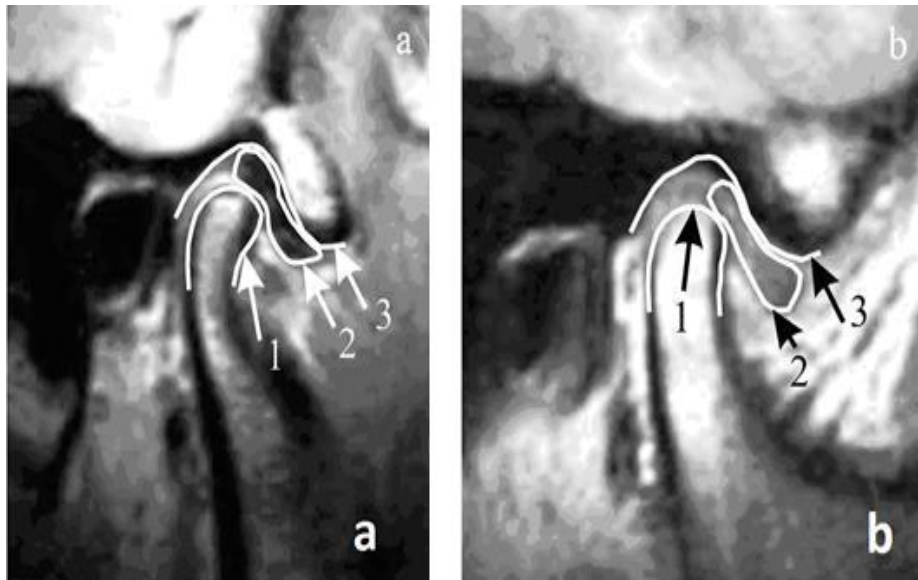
MRI image of the temporomandibular joint : (a) disk is in normal position; (b) anterior displacement of the disc (pathology) (1 is condyle; 2 is disk; 3 are glenoid fossa and tubercle of the temporal bone) (V Nikitin,2016)
